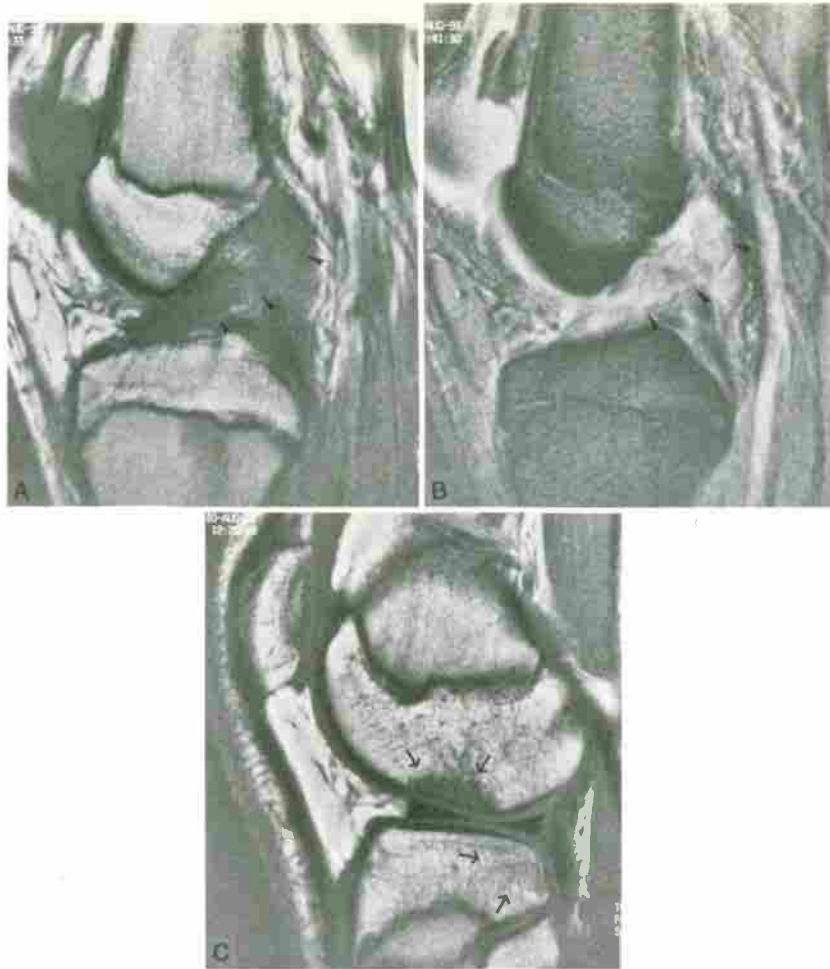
Acute, complete tear of anterior cruciate ligament (ACL) with bone contusions. A, Sagittal T1-weighted (TR/TE, 420/20) image through lateral aspect of intercondylar notch shows a mass of edema (arrowheads) in the expected location of the ACL. B, Corresponding gradient-echo (TR/TE, 442/18; angle, 30 degrees) sagittal image. C, In the same patient, sagittal T1-weighted (TR/TE, 420/20) image through the lateral joint compartment demonstrates "kissing contusions" (arrows) of the posterior aspect of the lateral tibial plateau and the lateral femoral condyle just above the anterior horn of the lateral meniscus.
